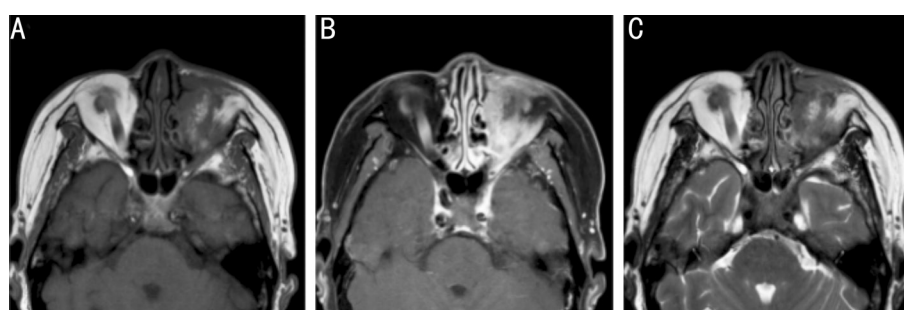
Case 4 Patient's orbital MRI irregularly shaped slightly long T1 (A) and iso-T2 (C) signal shadows with poorly defined borders are seen in the inner and lower quadrant of the left orbit in the interstitial space between the muscle cones. The lesion involves the internal rectus muscle, inferior rectus muscle, inferior oblique muscle and external rectus muscle, which are significantly strengthened after enhancement scan (B). The dynamic intensification curve is of a continuous strengthening type. The lesion involved the orbital apex, superior orbital fissure, inferior orbital fissure and the left cavernous sinus region posteriorly, and destroyed the orbital wall and nasolacrimal duct bone inwardly, involving the lacrimal sac region and nasolacrimal duct. Enhanced scan shows widening enhancement of the left cavernous sinus. Bone destruction of the inferior orbital wall was seen inferiorly, and the lesion was sequential to the lesion in the ipsilateral maxillary sinus. The ipsilateral subcutaneous soft tissues of the maxillofacial area were involved, with poorly defined borders and marked enhancement. The left eye was protruding, and the ocular contents did not show conduction. MRI: Magnetic resonance imaging.
